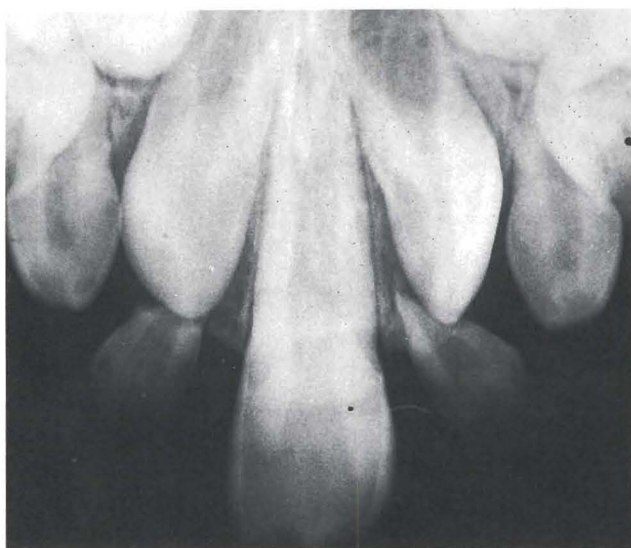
Case 1 periapical radiograph taken before shedding of tooth 52. Note normal shape of a left single incisor with an open apex in the midline.
